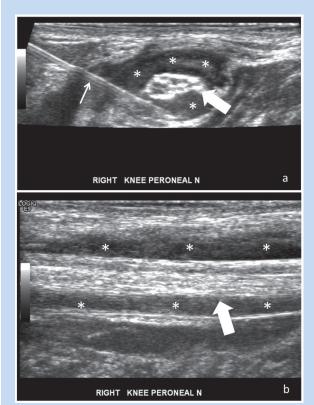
Ultrasound (US)-guided hydrodissection of the common peroneal nerve in a patient with radicular dorsolateral leg and foot weakness. (a) Transverse US image just proximal to the fibular head shows large volume injectant (*) circumferentially dissecting away tissues around the common peroneal nerve (block arrow) during hydrodissection. (b) Longitudinal US image of the common peroneal nerve (block arrow) after hydrodissection demonstrates injectant (*) along the superficial and deep surface of the nerve. Small arrow, 25-gauge needle.
